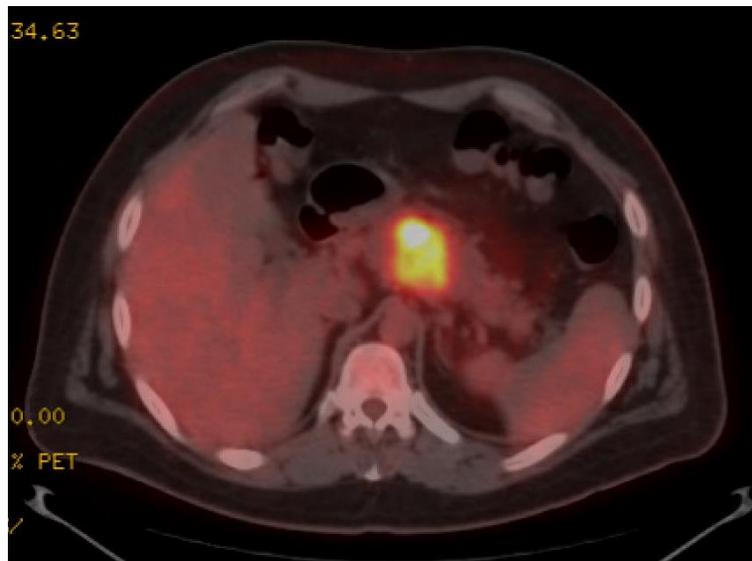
Axial fused image of PET/CT study shows the avid FDG-uptake in the predominantly cystic pancreatic body lesion.
